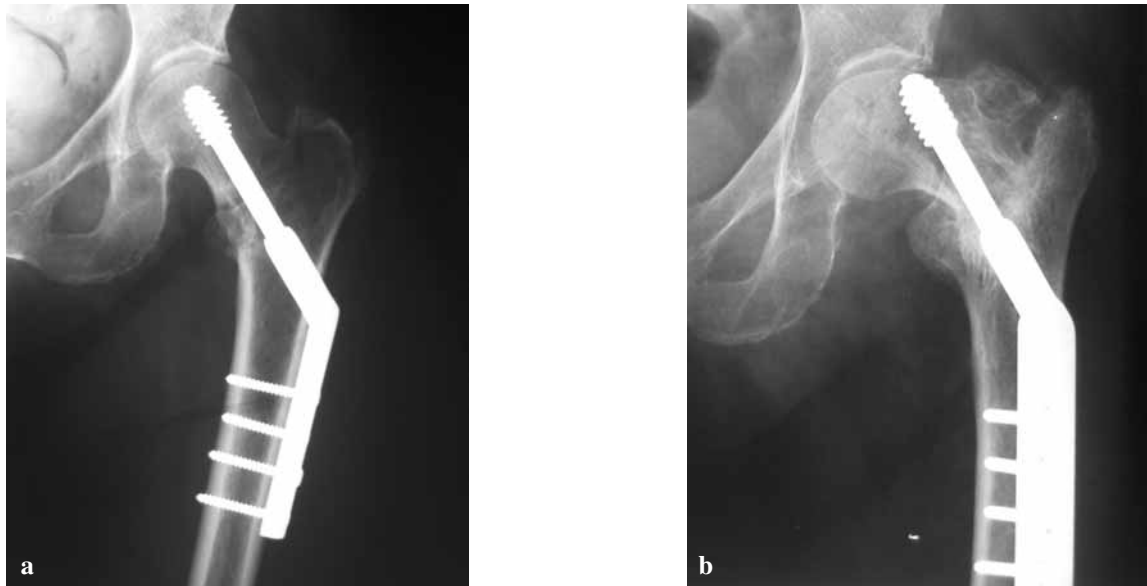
Internal fixation of a trochanteric fracture with a DHS™-type implant. a : Immediate postoperative radiograph showing good centering of the neck screw ; b : Cut-out at 3 weeks.
